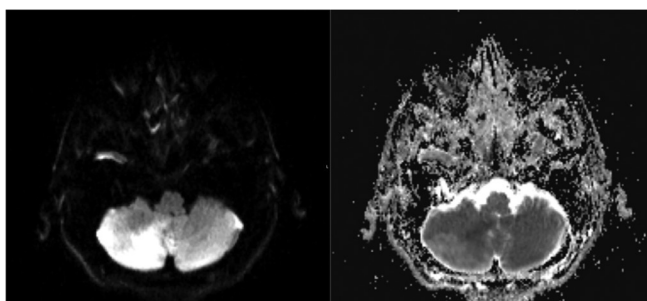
Serebellar enfarkt MRI
